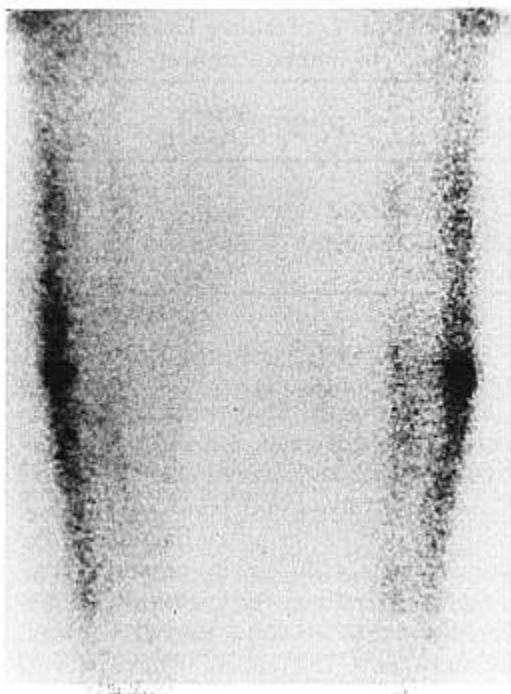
Radionuclide bone scan positive for bilateral tibial stress fractures. (Reprinted with permission from Pavlov, H., Torg, J. S., Hersh, A., and Freiburger, R. H.: The roentgen examination of runners' injuries. *Radiographics* 1:17, 1981.)
